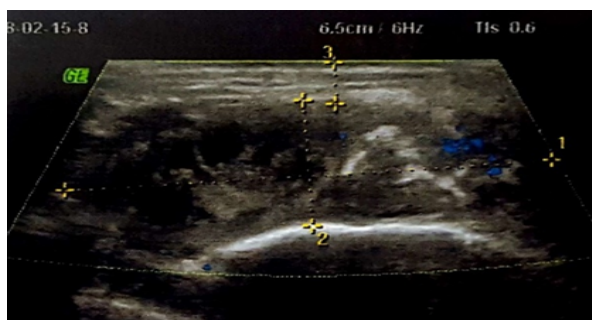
Ultrasonography showing the hypoechoic submasseteric hematoma.
